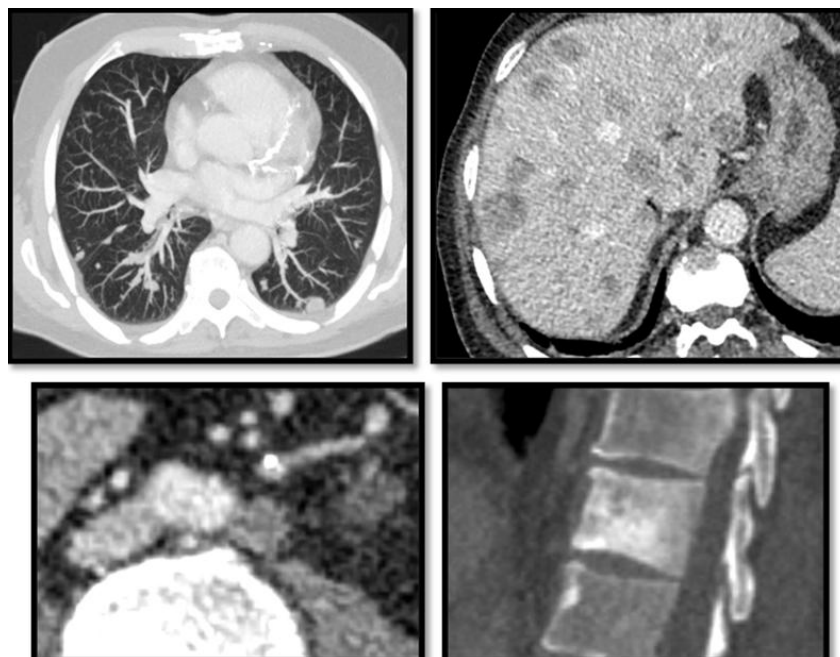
Thoracic-abdominal-pelvic enhanced CT scan showing lung, liver, bone and para-aortic lymph node metastases
